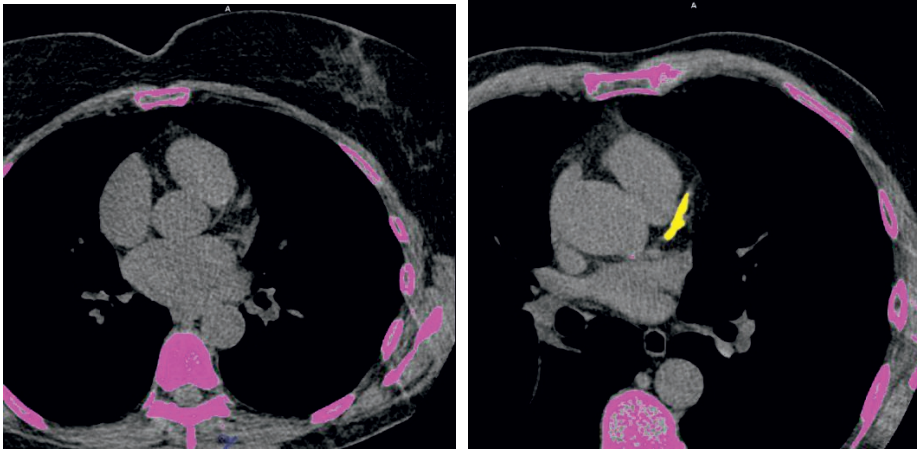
Computed tomography images of the chest for quantification of coronary artery calcification (CAC). Left: CAC score of 0, right: calcifications are highlighted in yellow; CAC score of ≥ 1000 .
